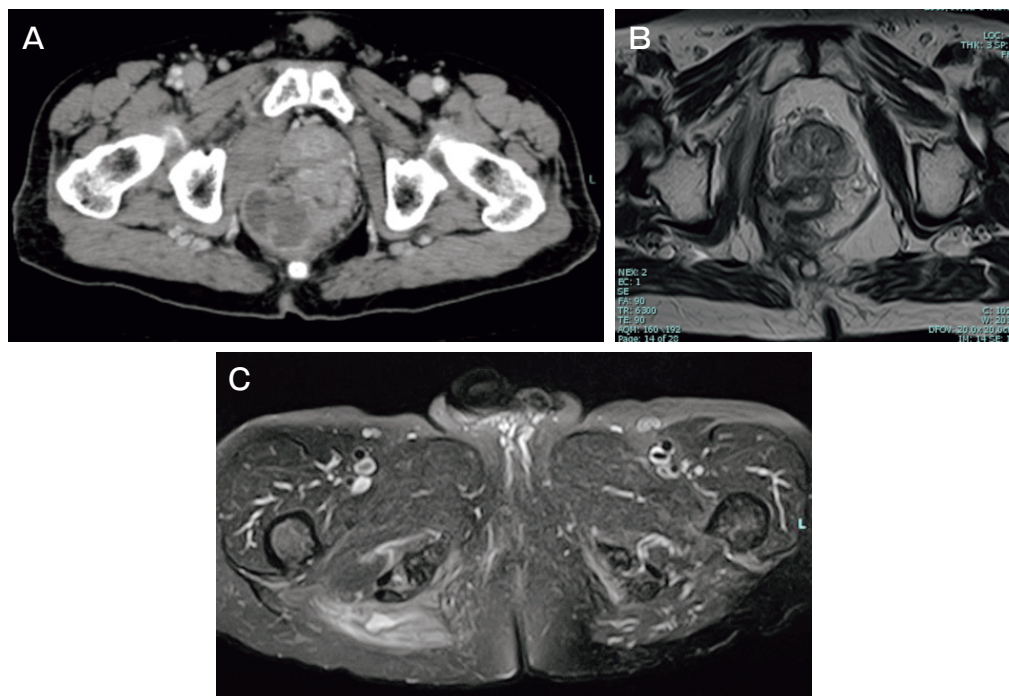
Pelvic CT and MRI findings. A, There was marked wall thickening in the lower rectum with abscess formation; B, A continuous high-intensity area was observed from the right side of the lower rectum to the perirectal area; C, An abscess formation was identified in the right gluteus maximus muscle with a high-intensity mass.
